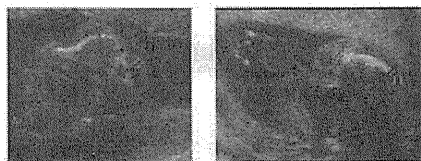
Two-dimensional ultrasonography of the fetal femur (a) and humerus (b). The bones are short and curved.
